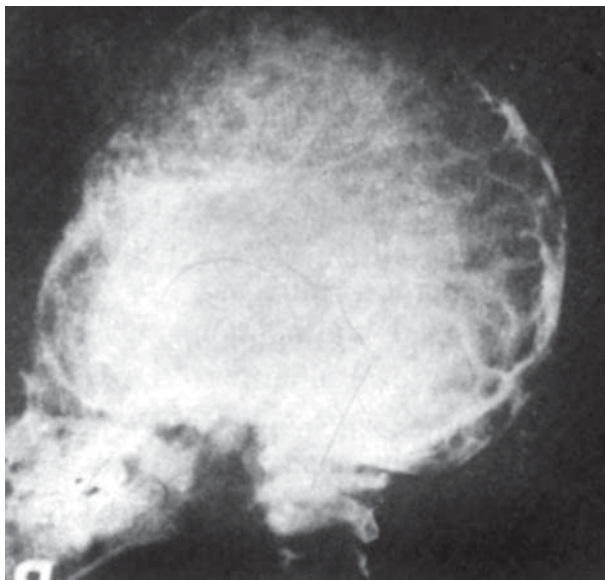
Skull X-ray in craniosynostosis. Note the oxycephalic skull with silver/copper-beaten appearance secondary to raised ICP.
